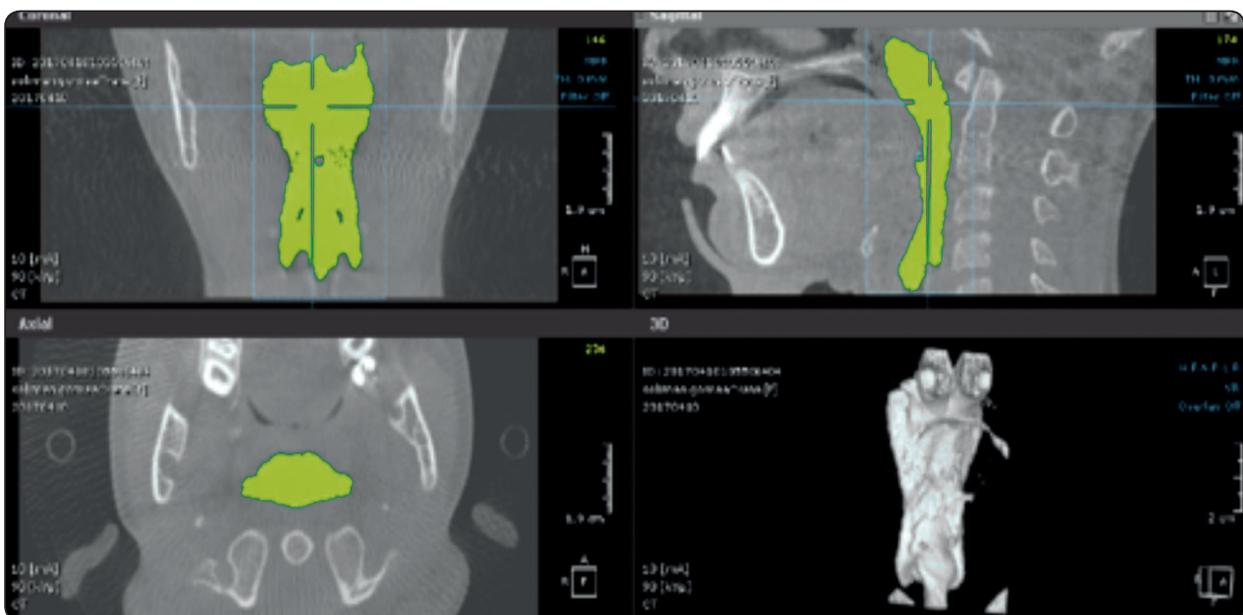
CBCT image revealing a defined and colored pharyngeal airway space in the axial, coronal and sagittal planes according to the threshold level.
